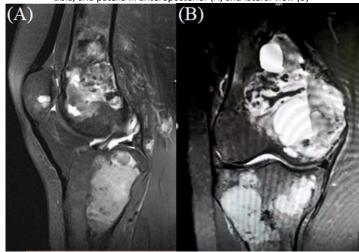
Lytic-destructive zones consisting of widespread cystic areas which craniocaudal size reaching 7.5 centimeters (cm) at the sagittal (B) coronal (A) plane of MRI scan
